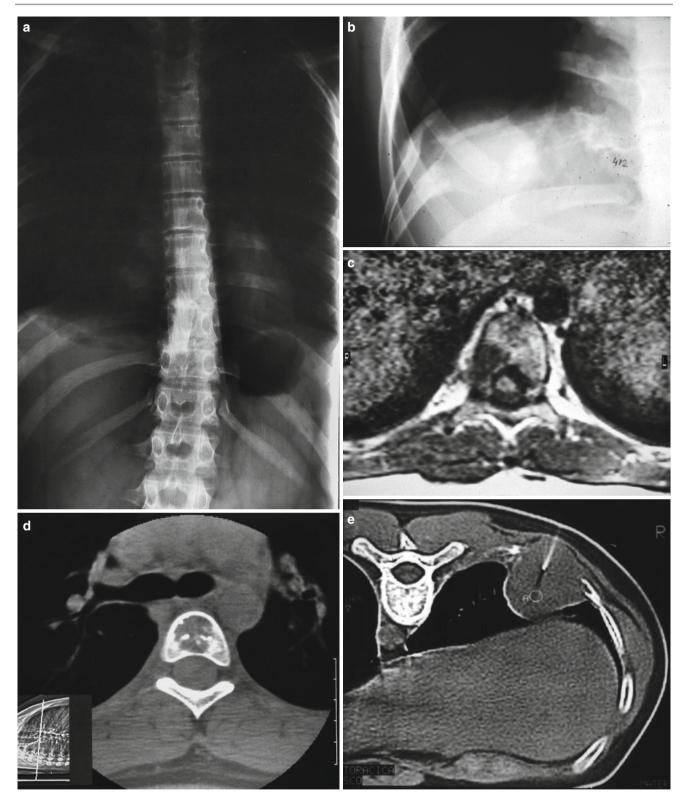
Multifocal EH. (a and b) Radiographs showing lesions in vertebrae and a rib. (c and d) MRI and CT of a vertebral lesion. (e) CT-guided needle biopsy of the rib lesion
